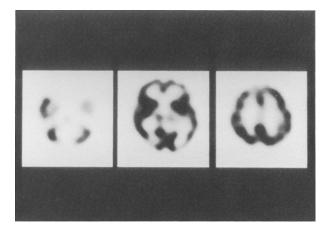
Tc-99m ECD-SPECT on postoperative day 68 shows cerebral blood flow (CBF) increased in the right thalamus, bilateral medial frontal lobes and left temporal lobe. Bilateral crossed cerebello-cerebral diaschisis is improved, with only a slight decrease of CBF still persisting in the left thalamus.
